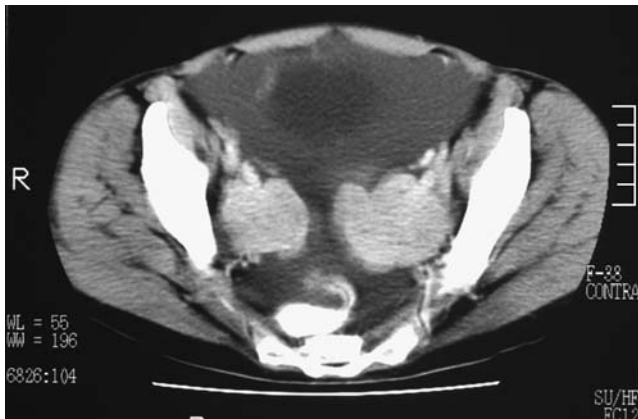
CT scan of tumors
